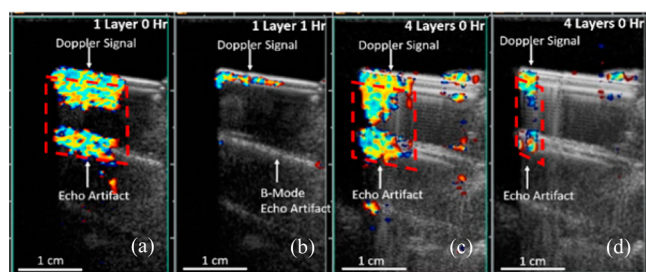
Color Doppler images of silica PMCA/microshells macrophase-separated films on a glass slide. A 15L8 transducer was used, and 7.0 MHz frequency was employed. (a, c) Images of a one- and four-layer film recorded at the beginning of the test, respectively. (b, d) Respective images recorded after the films were exposed to the US for 1 h. The second and third images below the initial signal are artifacts due to the strong acoustic echo.
